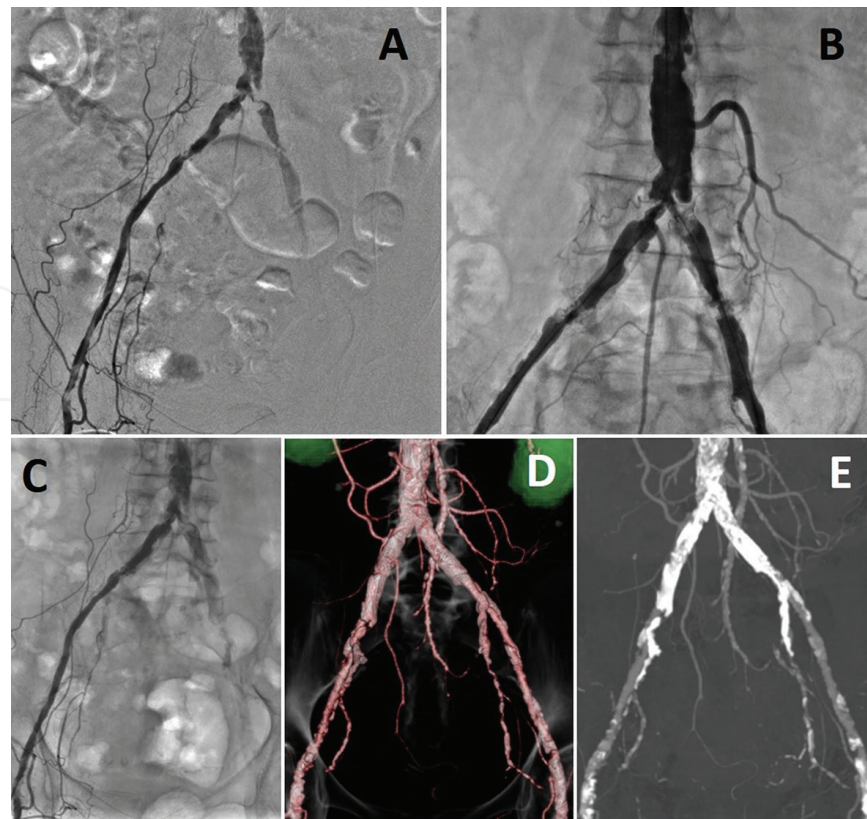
Heavily calcified aortic bifurcation disease involving orifices of bilateral CIA. (A) Extensive heavily calcified stenosis from aortic bifurcation to both CIAs is shown in 30 cm DSA. (B) More precise information of lesion can be obtained from 20 cm DA. (C–E) In case with severe calcification, CT angiogram is not suited as diagnostic or assessment tool since details of intravascular conditions due to calcification not visualized.
